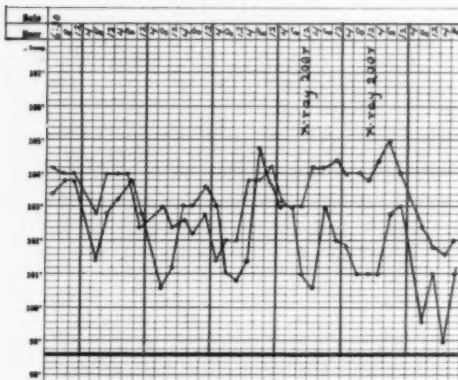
Lobar pneumonia of right lung. Sulfonamide therapy for first four hospital days with no improvement. Irradiation, 200 roentgens to right anterior chest, at noon on fourth hospital day, and a second roentgen treatment 24 hours later, with usual response and full recovery by rapid lysis.
